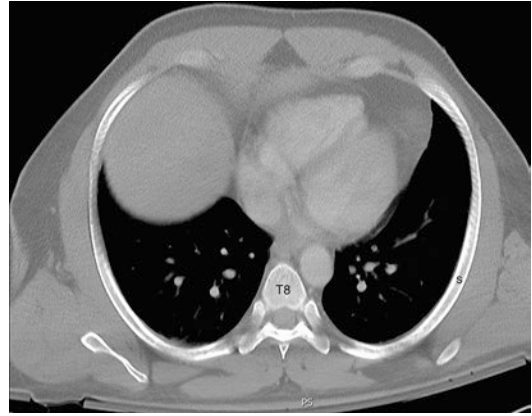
Anatomy of a false rib. Axial CT image reconstructed in the oblique axial plane at the T8 level shows the anatomic parts of the eighth rib. These are identical to those of the true rib, but there is no direct articulation with the sternum. The shaft(s) is well seen
